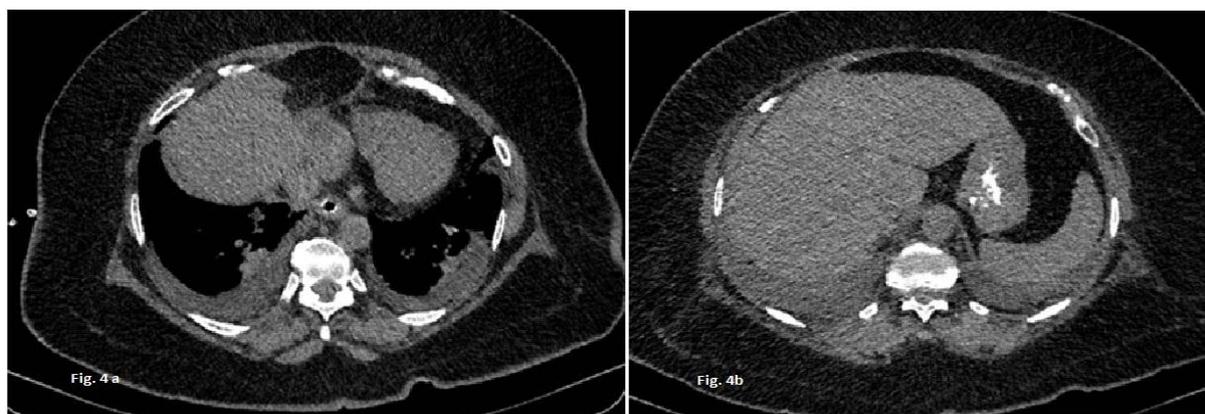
(a) Axial CT showing bilateral pleural effusions. Distal esophagus appears normal. (b) Axial CT image showing normal stomach.
